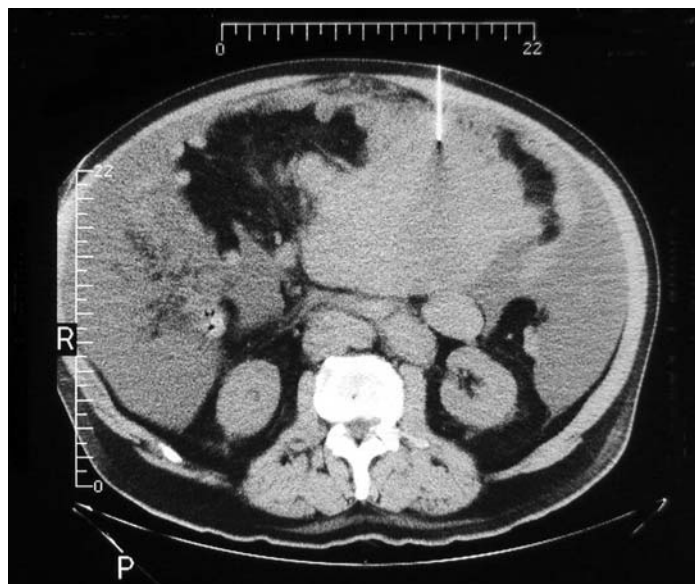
In a percutaneous biopsy of a large abdominal mass, CT guidance is a reliable means of determining the direction and depth of the needle.
